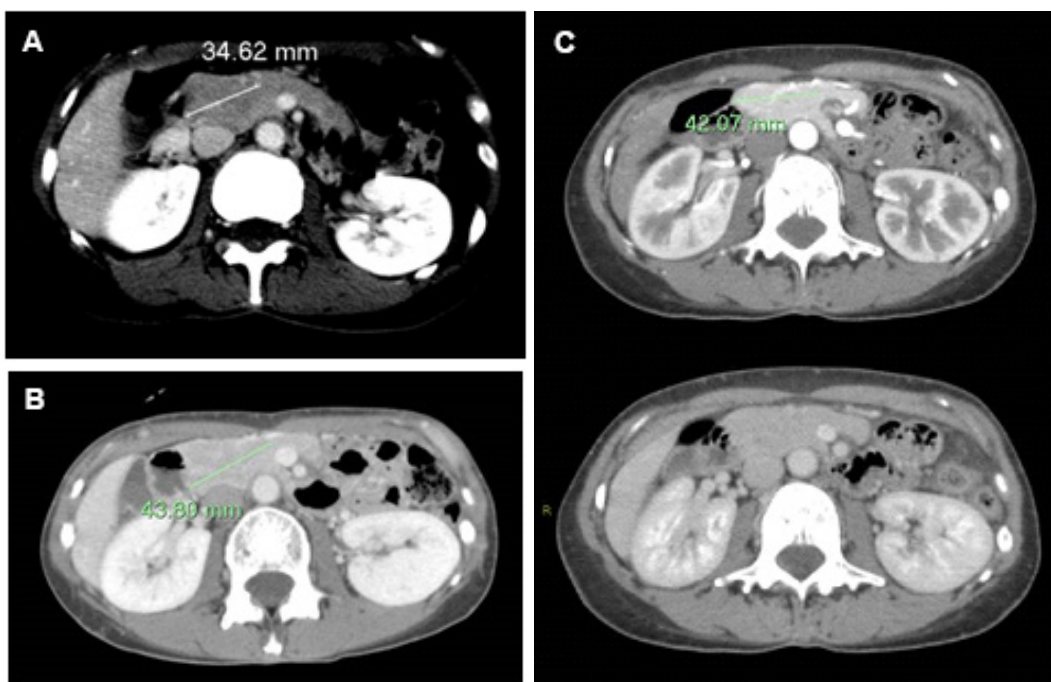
Computed tomography (CT) scans of our patient. A) Scan in 2011 showing lesion in head of pancreas about 35 mm in size. B) Arterial and delayed phase scan in 2013, showing draping of vessels around isodense lesion in head of pancreas. C) Latest scan in 2016, again showing isodense lesion about 44 mm in size.
